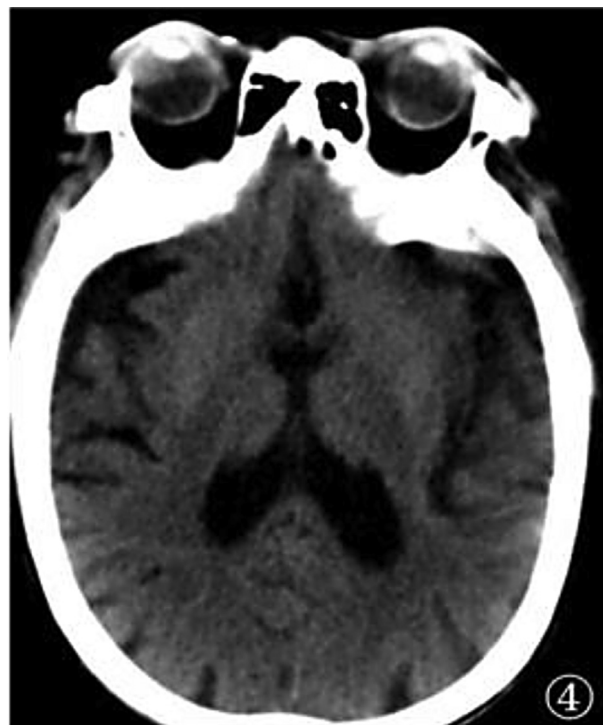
CT: Slightly high-density changes in bilateral striatum.
